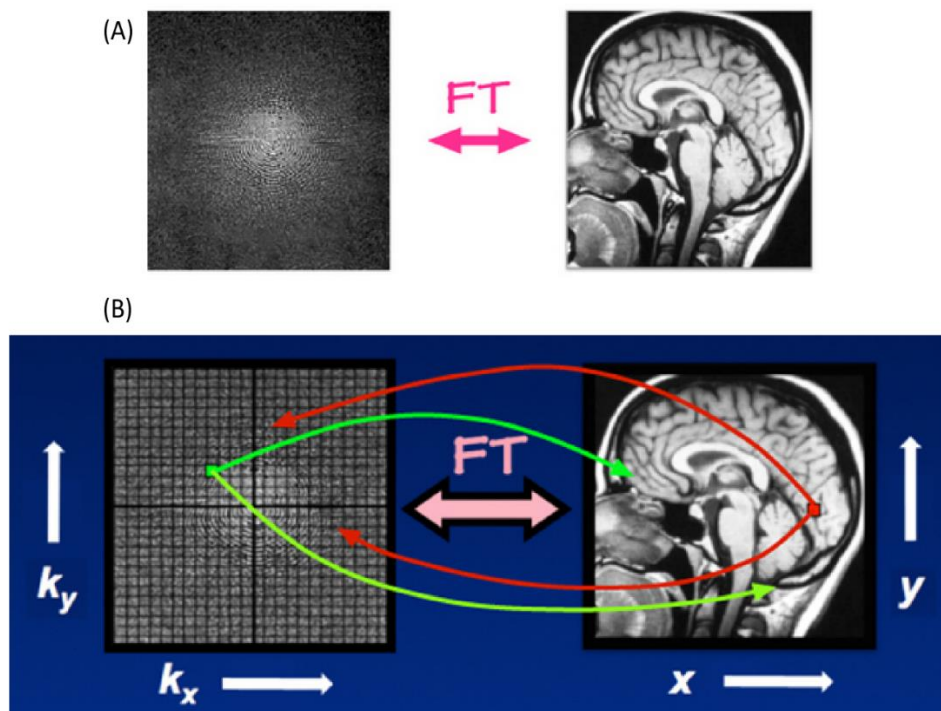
(A) The k -space is the Fourier transformation of the MR image and vice-versa. (B) Each data point in the k -space consists of the sum of the MR signal from all pixels in the image space (Adapted from Elster (2021g)).
